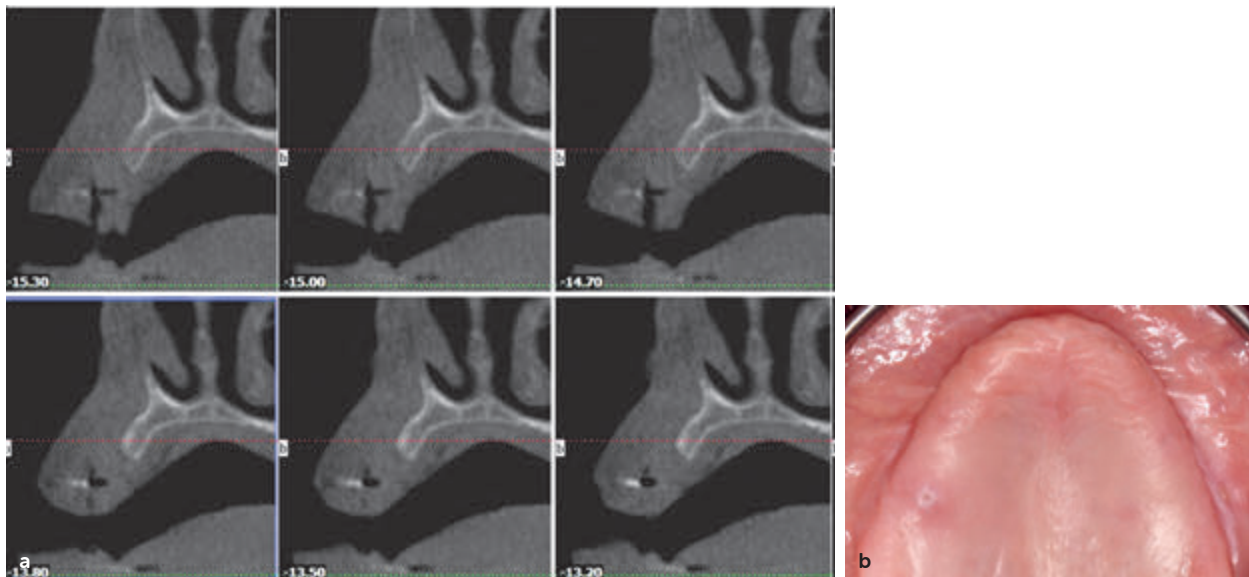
(a) A preoperative CT scan reveals a narrow ridge in the edentulous maxilla. (b) Preoperative occlusal view of the atrophic maxilla.
